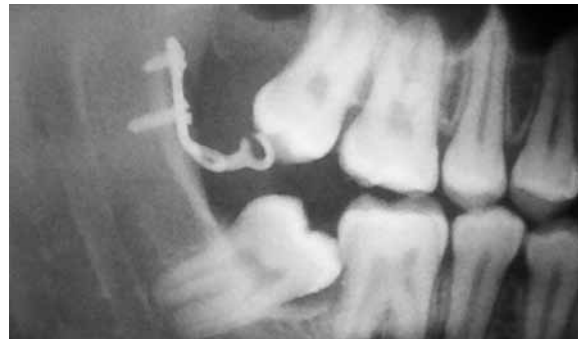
Radiograph obtained immediately after miniplate fixation and before orthodontic movement was initiated.
